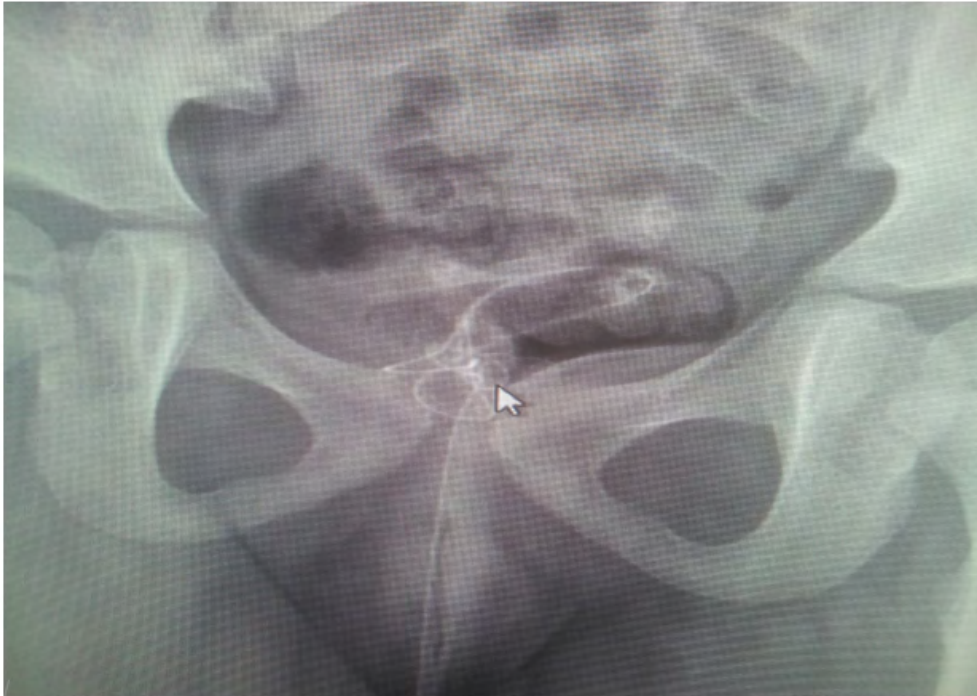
Radiograph showing the knotted catheter in the bladder (Arrow: the knot).
